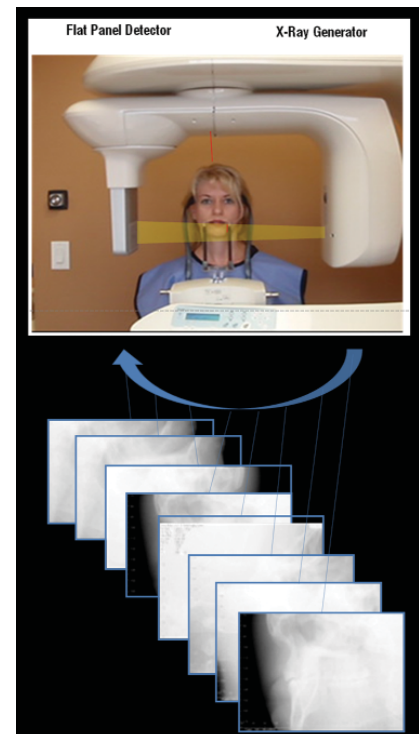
Acquisition of CBCT images consists of a pyramidal or cone shaped x-ray beam directed through a volume of interest in the patient is recorded by a digital receptor. As the apparatus rotates multiple basis images are acquired, forming the dataset.
